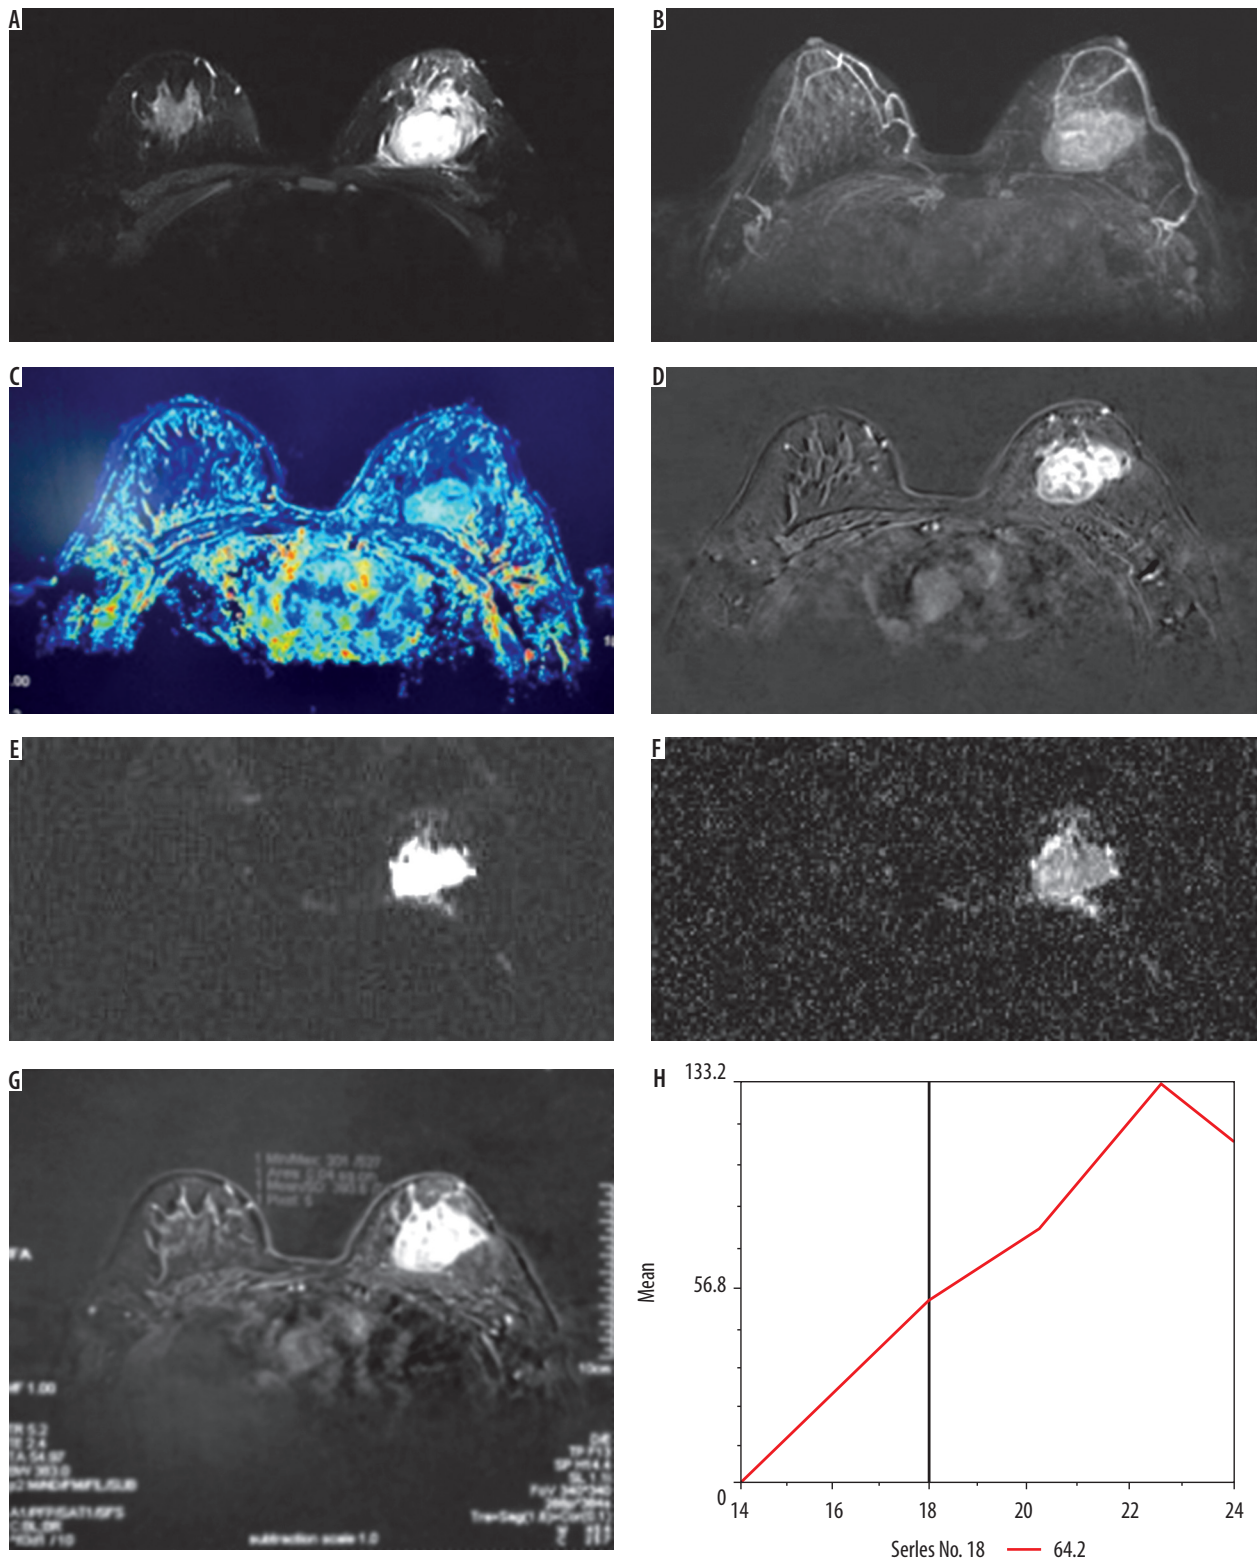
Magnetic resonance breast imaging in a case of ductal carcinoma in situ in a 65-year-old woman. A) Axial STIR image of the breast showing a well-defined heterogeneous, hyperintense mass seen in the left breast. B) Maximum intensity projection image showing heterogeneous enhancement of the lesion. C) Wash-in colour map. D) Post-contrast axial fat sat T1WI image showing intense heterogeneous enhancement of the mass. E) Axial diffusion weighted imaging (DWI) showing hyperintense signals in the mass with F) corresponding low apparent diffusion coefficient value (restriction on DWI). G-H) Time signal intensity curve of the mass showed type III kinetic curve (early washout)
